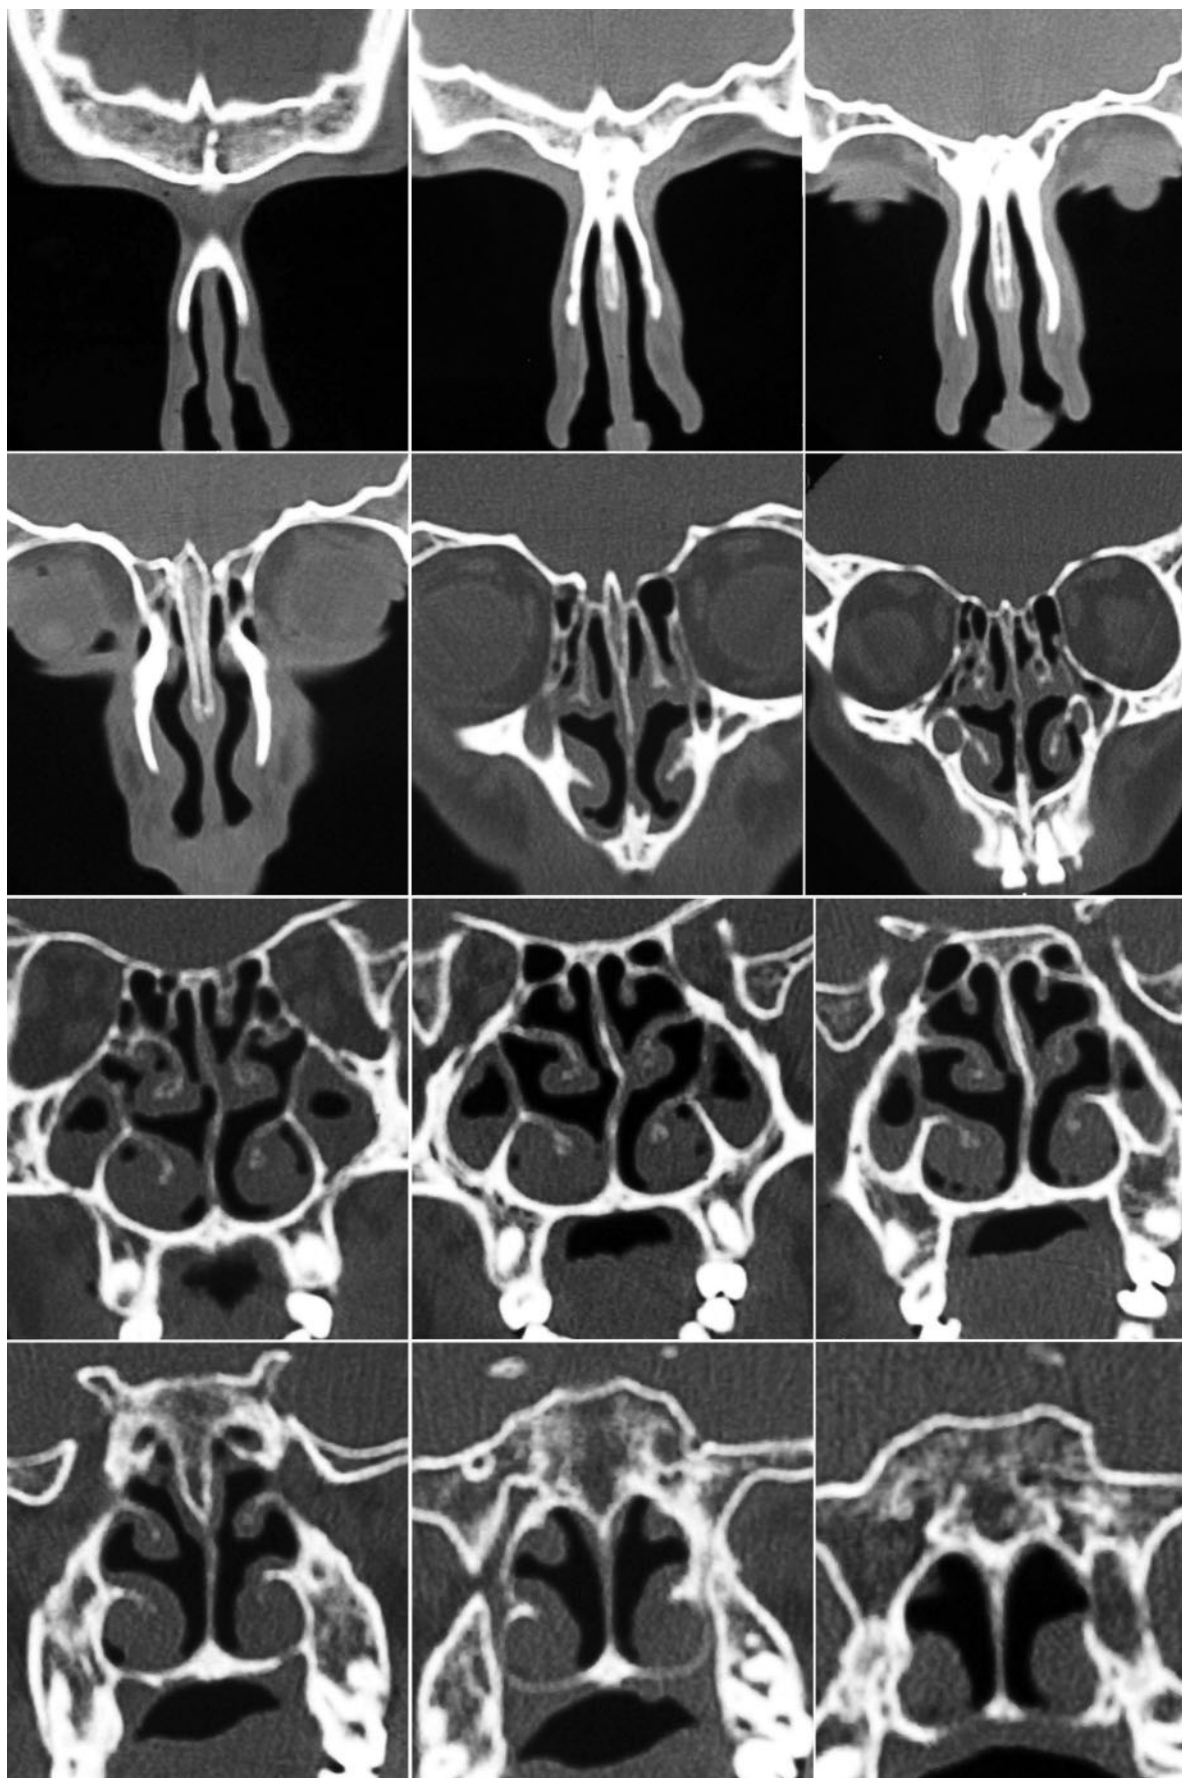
Sequential CT slices of paranasal sinuses in coronal plane shows the same findings in Figure 1: bilateral hypoplastic maxillary and ethmoid sinuses and bilateral frontal and sphenoid sinus aplasias. A slight deviation of nasal septum towards the left side and bilateral soft tissue densities in maxillary sinuses are also seen.
